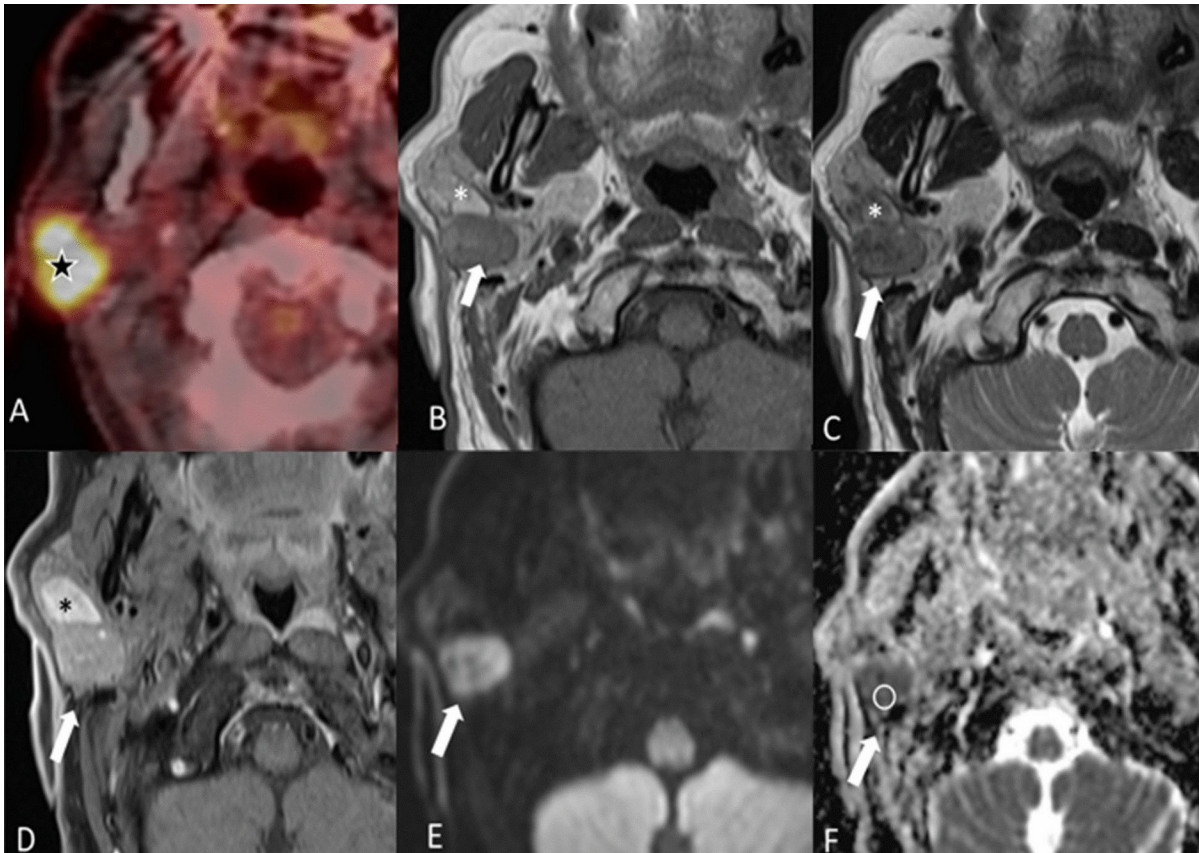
Warthin tumor may be intensely FDG avid and may restrict diffusion. PET avidity and low ADC are not synonymous with malignancy. Kim et al., BMC Medical Imaging 2022; CC BY 4.0.
